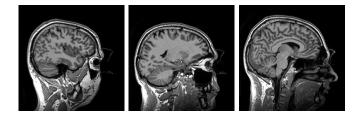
Several sagittal slices from our MRI data set comprising 248 slices.
